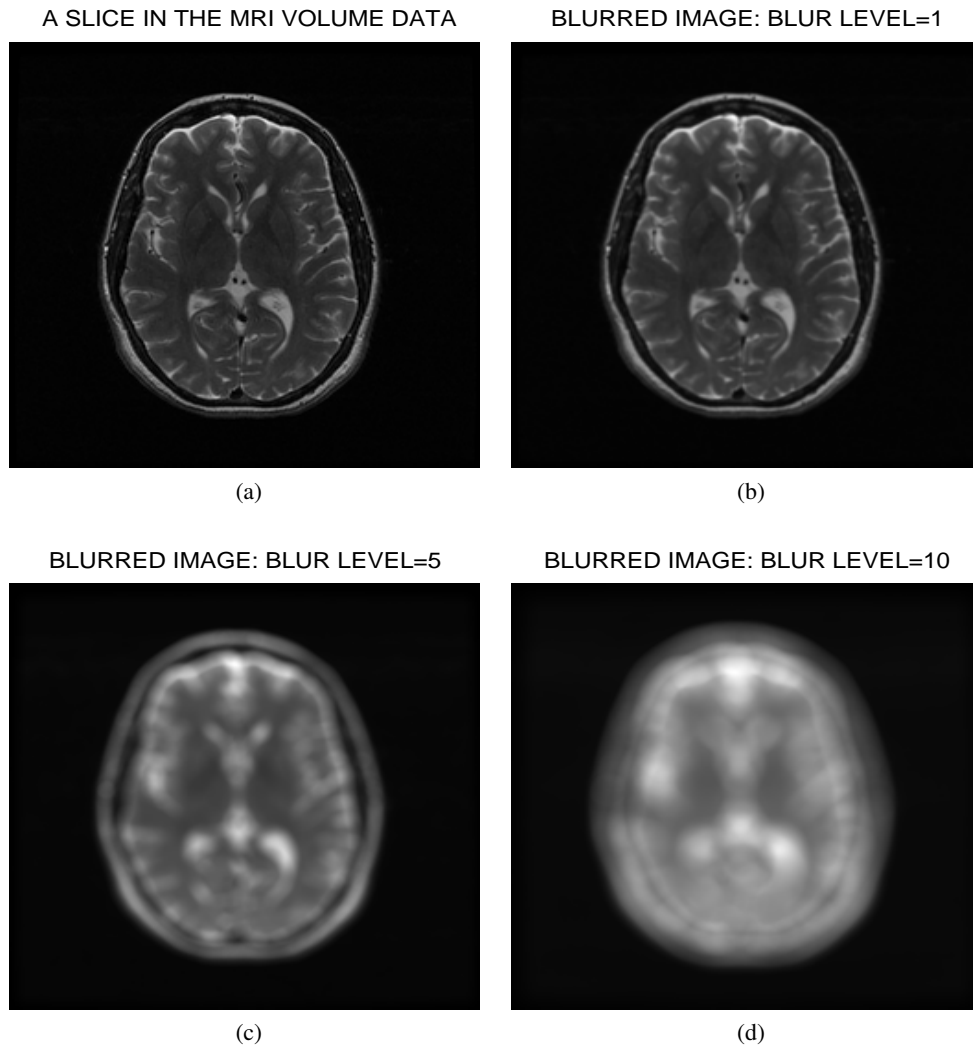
A slice in the MRI volume data without blur degradation (a). The same slice in (a) with different levels of blur degradation, (b) blur level =1, (c), blur level=5 and (d) blur level=10.
